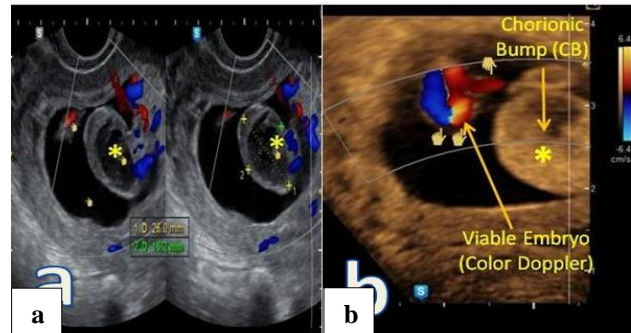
(a and b): CB by color Doppler transvaginal ultrasound. Note that the CB is avascular.
